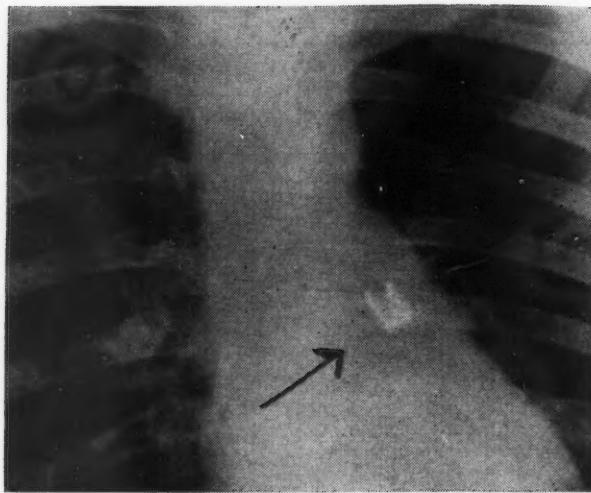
Tooth in the left bronchus. I.H., age 6 years. November 1, 1934. Two weeks previously tonsils and adenoids were removed and at the same time eight teeth were extracted. Shortly afterwards patient developed toxic symptoms, cough and respiratory distress. A chest radiograph revealed a tooth in the left bronchus. Direct bronchoscopy under Avertin anaesthesia. After aspiration of the pus and granulations from the left main bronchus, the tooth was visible, and was removed. Uneventful recovery.
